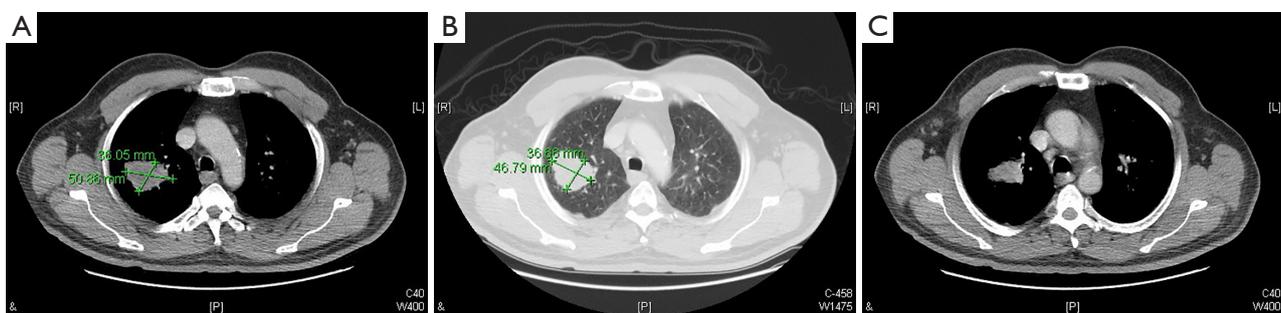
Chest CT scan (different windows views). (A) Chest CT scan (mediastinal window), showing the right upper lobe mass; (B) chest CT scan (pulmonary window), showing the right upper lobe mass; (C) chest CT scan, showing retrocaval (pretracheal large mediastinal lymph node). R, right; L, left; P, posterior.
